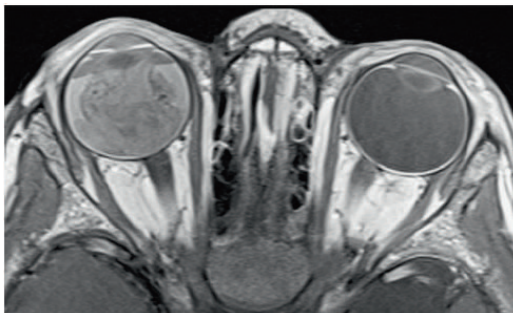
Transaxial contrast-enhanced T1-weighted (TR/TE, 722/14 ms) image obtained at 3.0 T using a 32-channel head coil shows an exophytic retinoblastoma with secondary total retinal detachment and proteinaceous subretinal effusion
